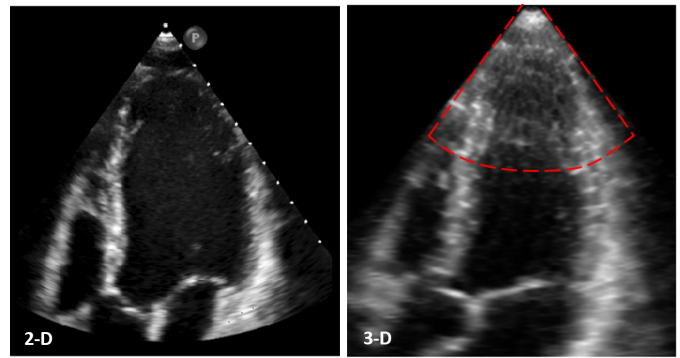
Transthoracic echoes displaying the increase in NF clutter artifacts in 3-D US with respect to 2-D acquisitions. (a) 2-D image obtained in an apical window. (b) 2-D slice of a similar view acquired within the same subject using 3-D US. The NF clutter region is enclosed by a red-dotted line.
